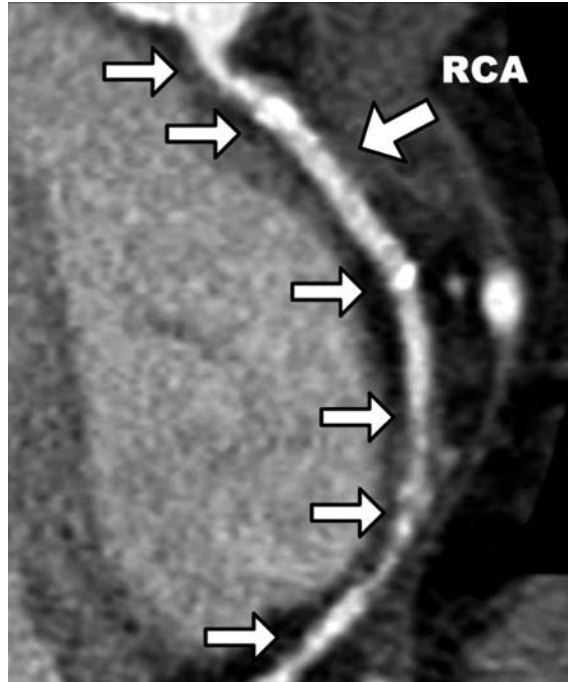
Patient-specific right coronary artery (RCA). Axial tomographic image which indicates a multiple coronary stenosis at the RCA (*arrows*) (64-slice CT).
